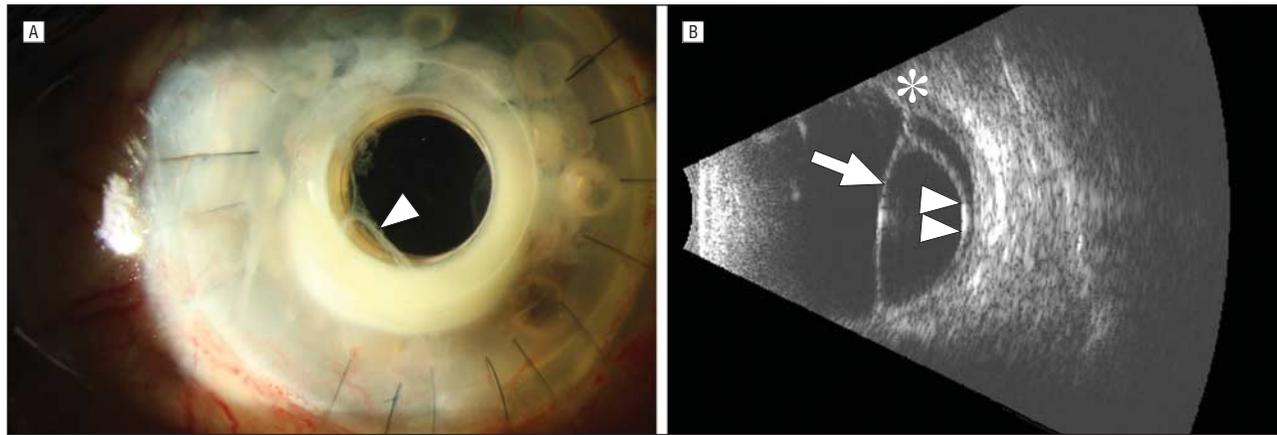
Clinical presentation of epithelial downgrowth. A, Slitlamp examination reveals an intraprosthetic membrane (arrowhead) posterior to the front plate, anterior to the back plate, and extending from the 6-o'clock position to the 10-o'clock position prior to vitrectomy. B, Diagnostic B-scan ultrasonography exhibited an anterior vitreous band (arrow) and tractional retinal detachment due to epiretinal membrane from epithelial downgrowth (arrowheads) and choroidal detachment (asterisk). The tractional retinal detachment induced by the epiretinal membrane was most prominent anteriorly but extended across the posterior pole.
